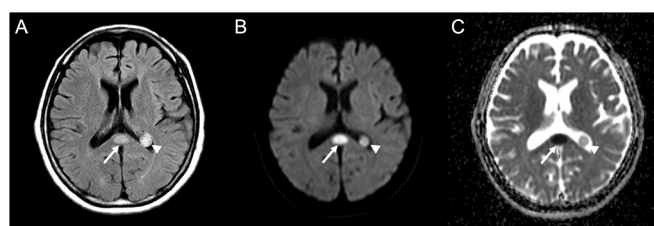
MRI revealed an oval lesion with slightly high signal intensity on T2 fluid-attenuated inversion recovery (Panel A), high signal intensity on diffusion weighted imaging (Panel B), and decreased apparent diffusion coefficient (ADC) value on ADC map (Panel C) in the splenium of the corpus callosum. A choroid plexus cyst was also incidentally shown in the left lateral ventricle (arrow heads).
